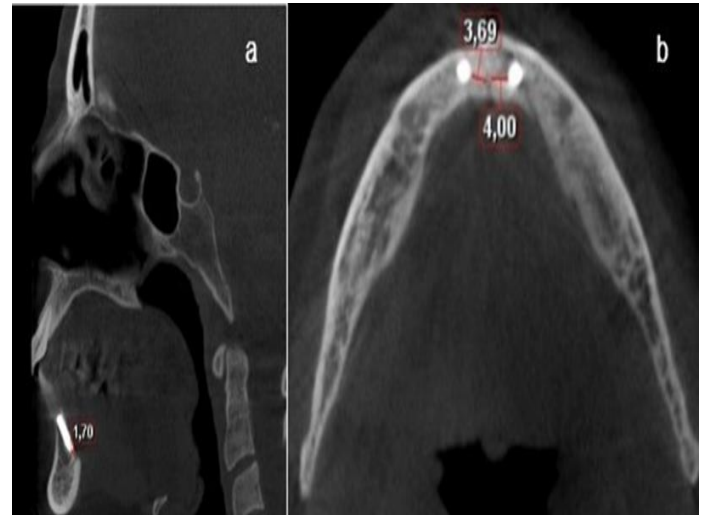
Relationship of the implants placed in the lingual foramen region with the lingual foramen in sagittal and axial section CBCT images (a) type 2, (b) type 3.
